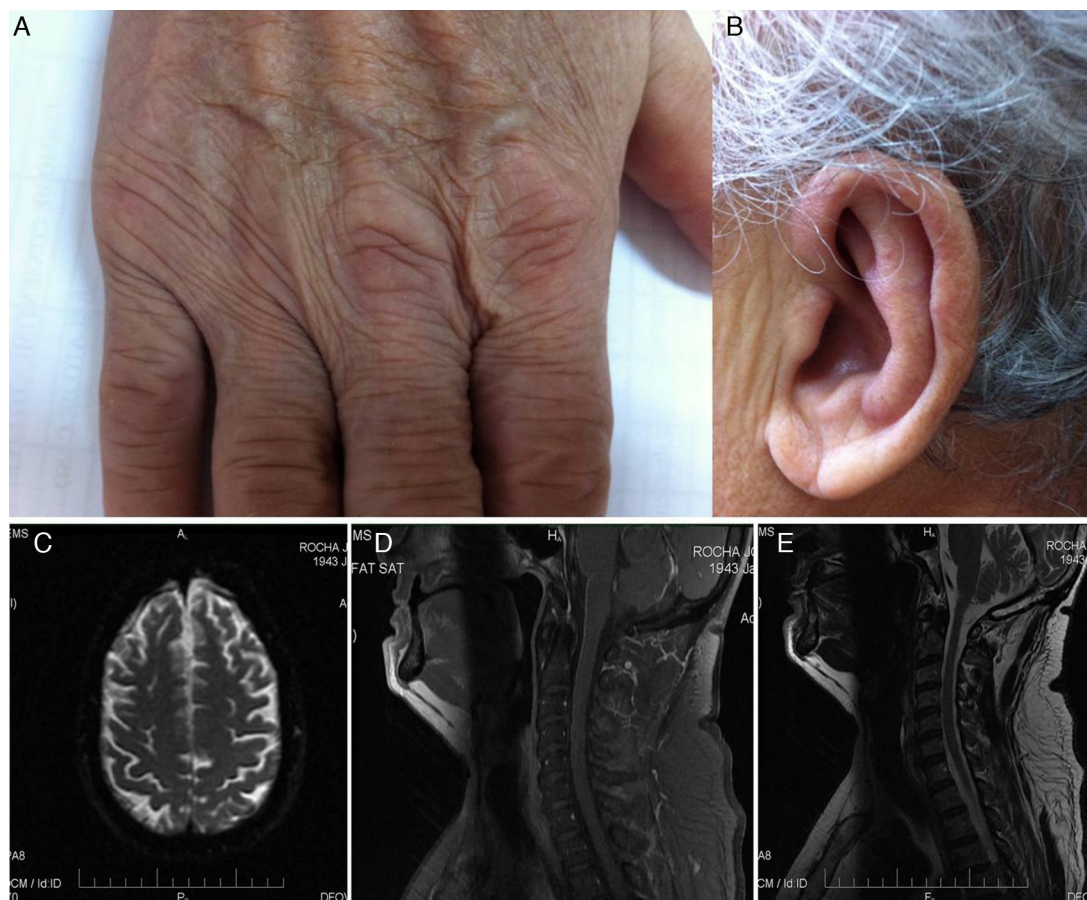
Rheumatological clinical findings (upper images): (A) edema of metacarpophalangeal joints; (B) ear lobe chondritis. Brain MRI findings (lower images): (C) axial diffusion with thickening of the dura of both frontal lobes; (D) sagittal T1 FSE FAT SAT with increased meningeal signal adjacent to the cerebellum; (E) T2 FSE showing mild cerebellar atrophy.
